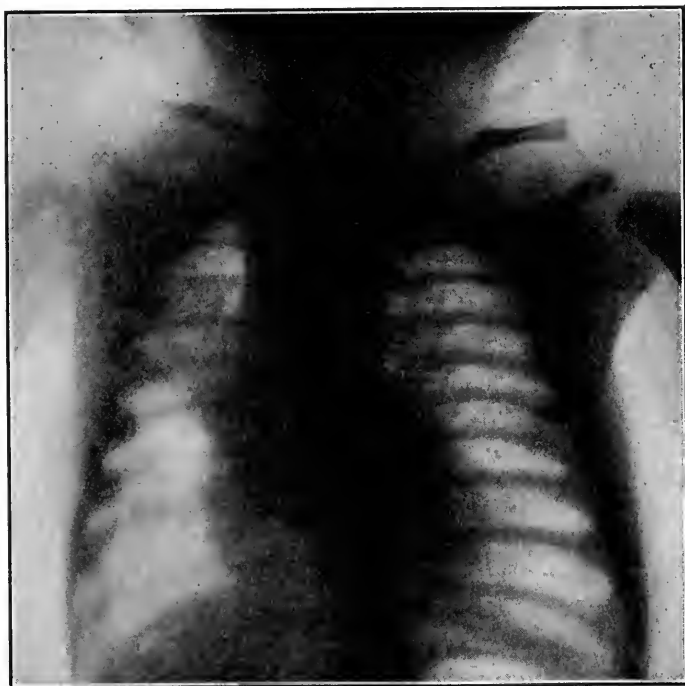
X-ray of chest showing the blind upper portion of the esophagus filled with a milk and barium mixture. The upper portion of the air-filled stomach can also be seen.
